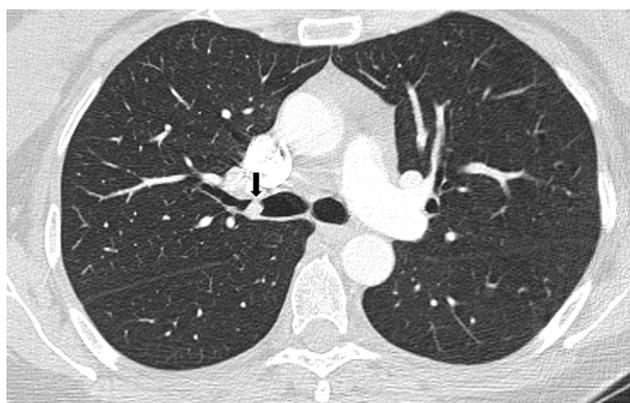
CT scan image with hyperdense lesion on main right bronchi.
